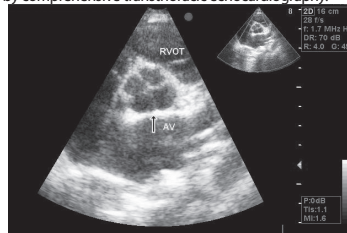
2-D echocardiography demonstrated classical X shape of quadricuspid aortic valve
